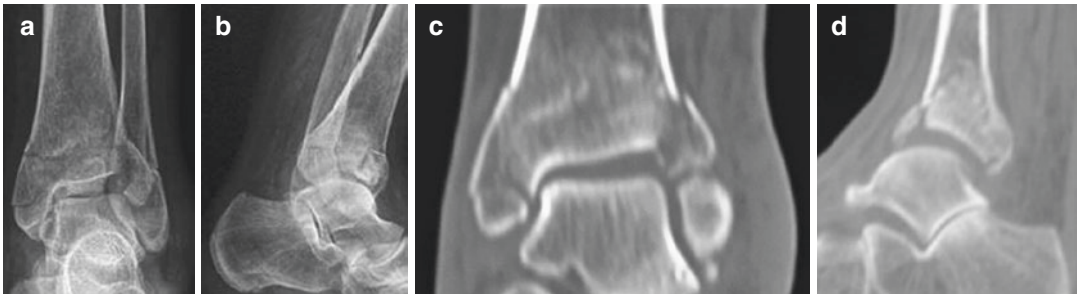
(a, b) Preoperative radiographs of an AO/OTA-type 43 B3 fracture in a 66-year-old female patient. (c, d) Preoperative reformatted coronary and sagittal CT images
